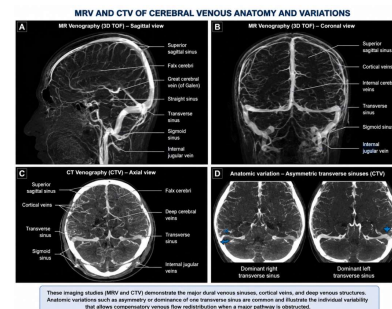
CT and MR Venographic Demonstration of Cerebral Venous Anatomy and Anatomical Variations
